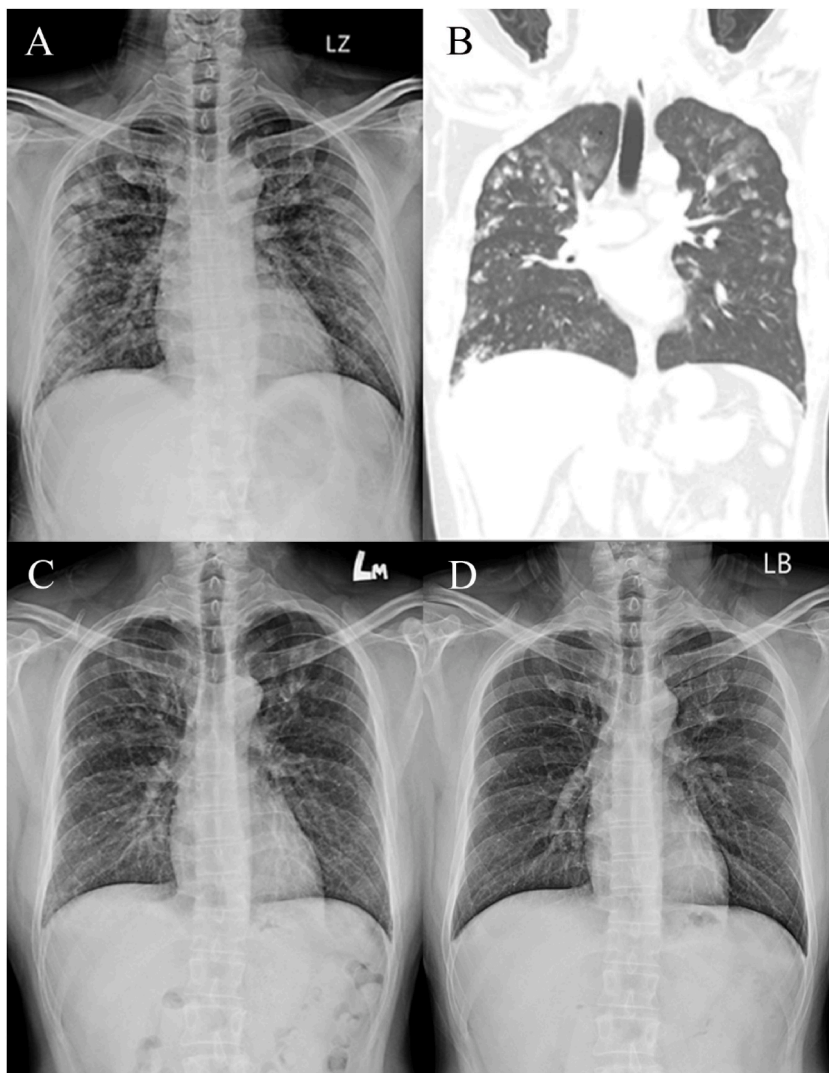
(A) CXR showed bilateral alveolar infiltrates predominantly in the peripheral and upper lung fields (B) CT further revealed peribronchial ground-glass opacities in addition to alveolar infiltrates (C) Subsequent CXRs showed marked regression of pulmonary infiltrates on day 2 and (D) on day 5.
